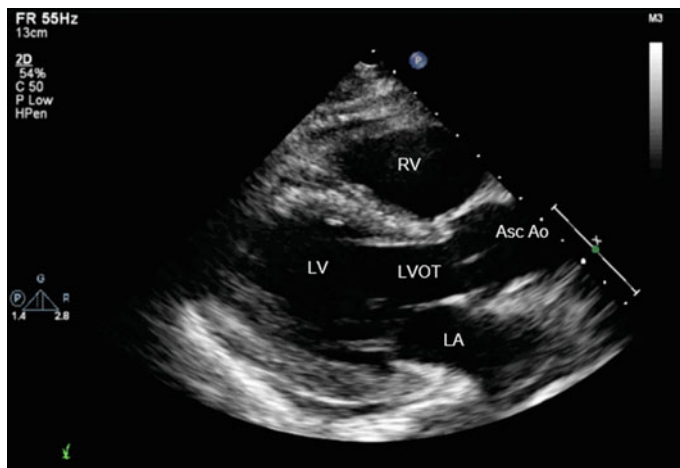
Parasternal LAX view. *LA* left atrium; *LV* left ventricle; *LVOT* left ventricular outflow tract; *RV* right ventricle; *Asc Ao* ascending aorta
